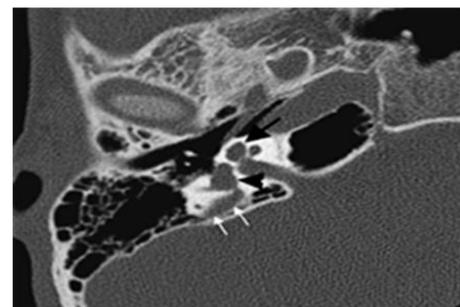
IP type II (Mondini malformation) Shown in the right axial CT scan of the right temporal showing the joining of the middle and apical grooves of the cochlea (black arrow). Large visible vestibule (arrowhead) and also visible widening of the vestibular aqueduct (white arrow)
